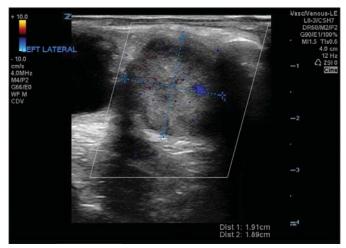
Ultrasound image measuring the heterogenous structure.*
